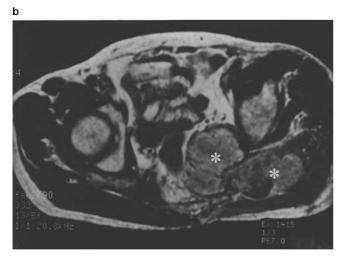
(a) Computed tomography scan showing tumourous lesions beneath the sciatic notch bilaterally (L, left side; asterisk, lesion). (b) T1-weighted magnetic resonance image (TR, 333 ms, TE, 13 ms) (asterisk, lesion). (c) coronal magnetic resonance image (T2-weighted; TR, 3600 ms, TE, 80 ms) showing the tumourous lesion extending bilaterally distal to the greater sciatic notches (R, right side)
